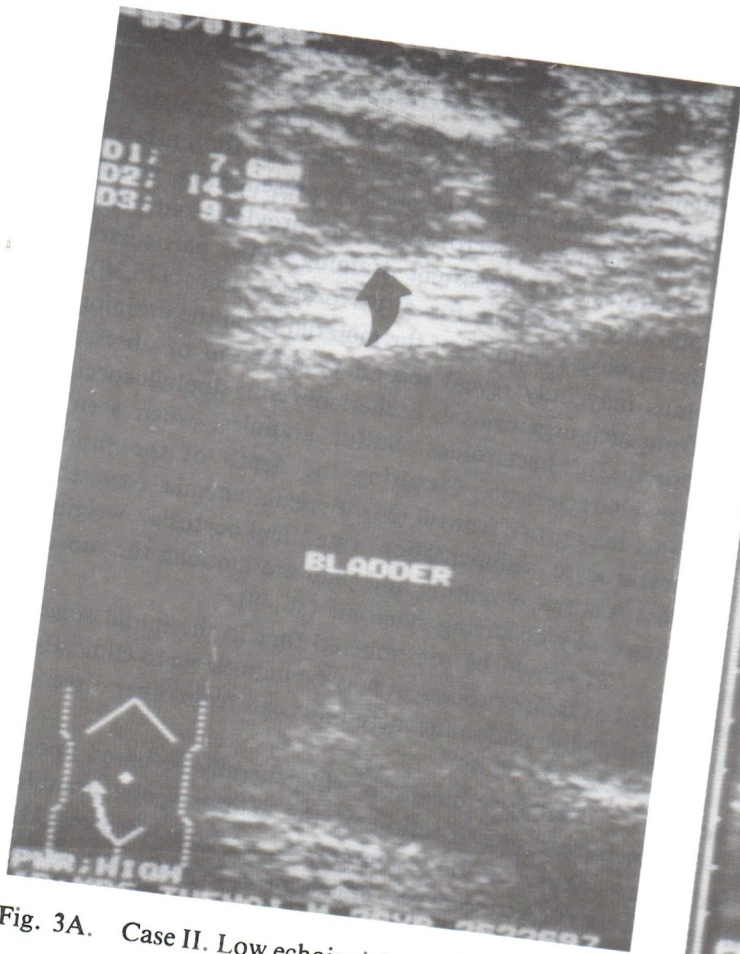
Case II. Low echoic right anterior abdominal wall lesion, at ultrasonogram.
